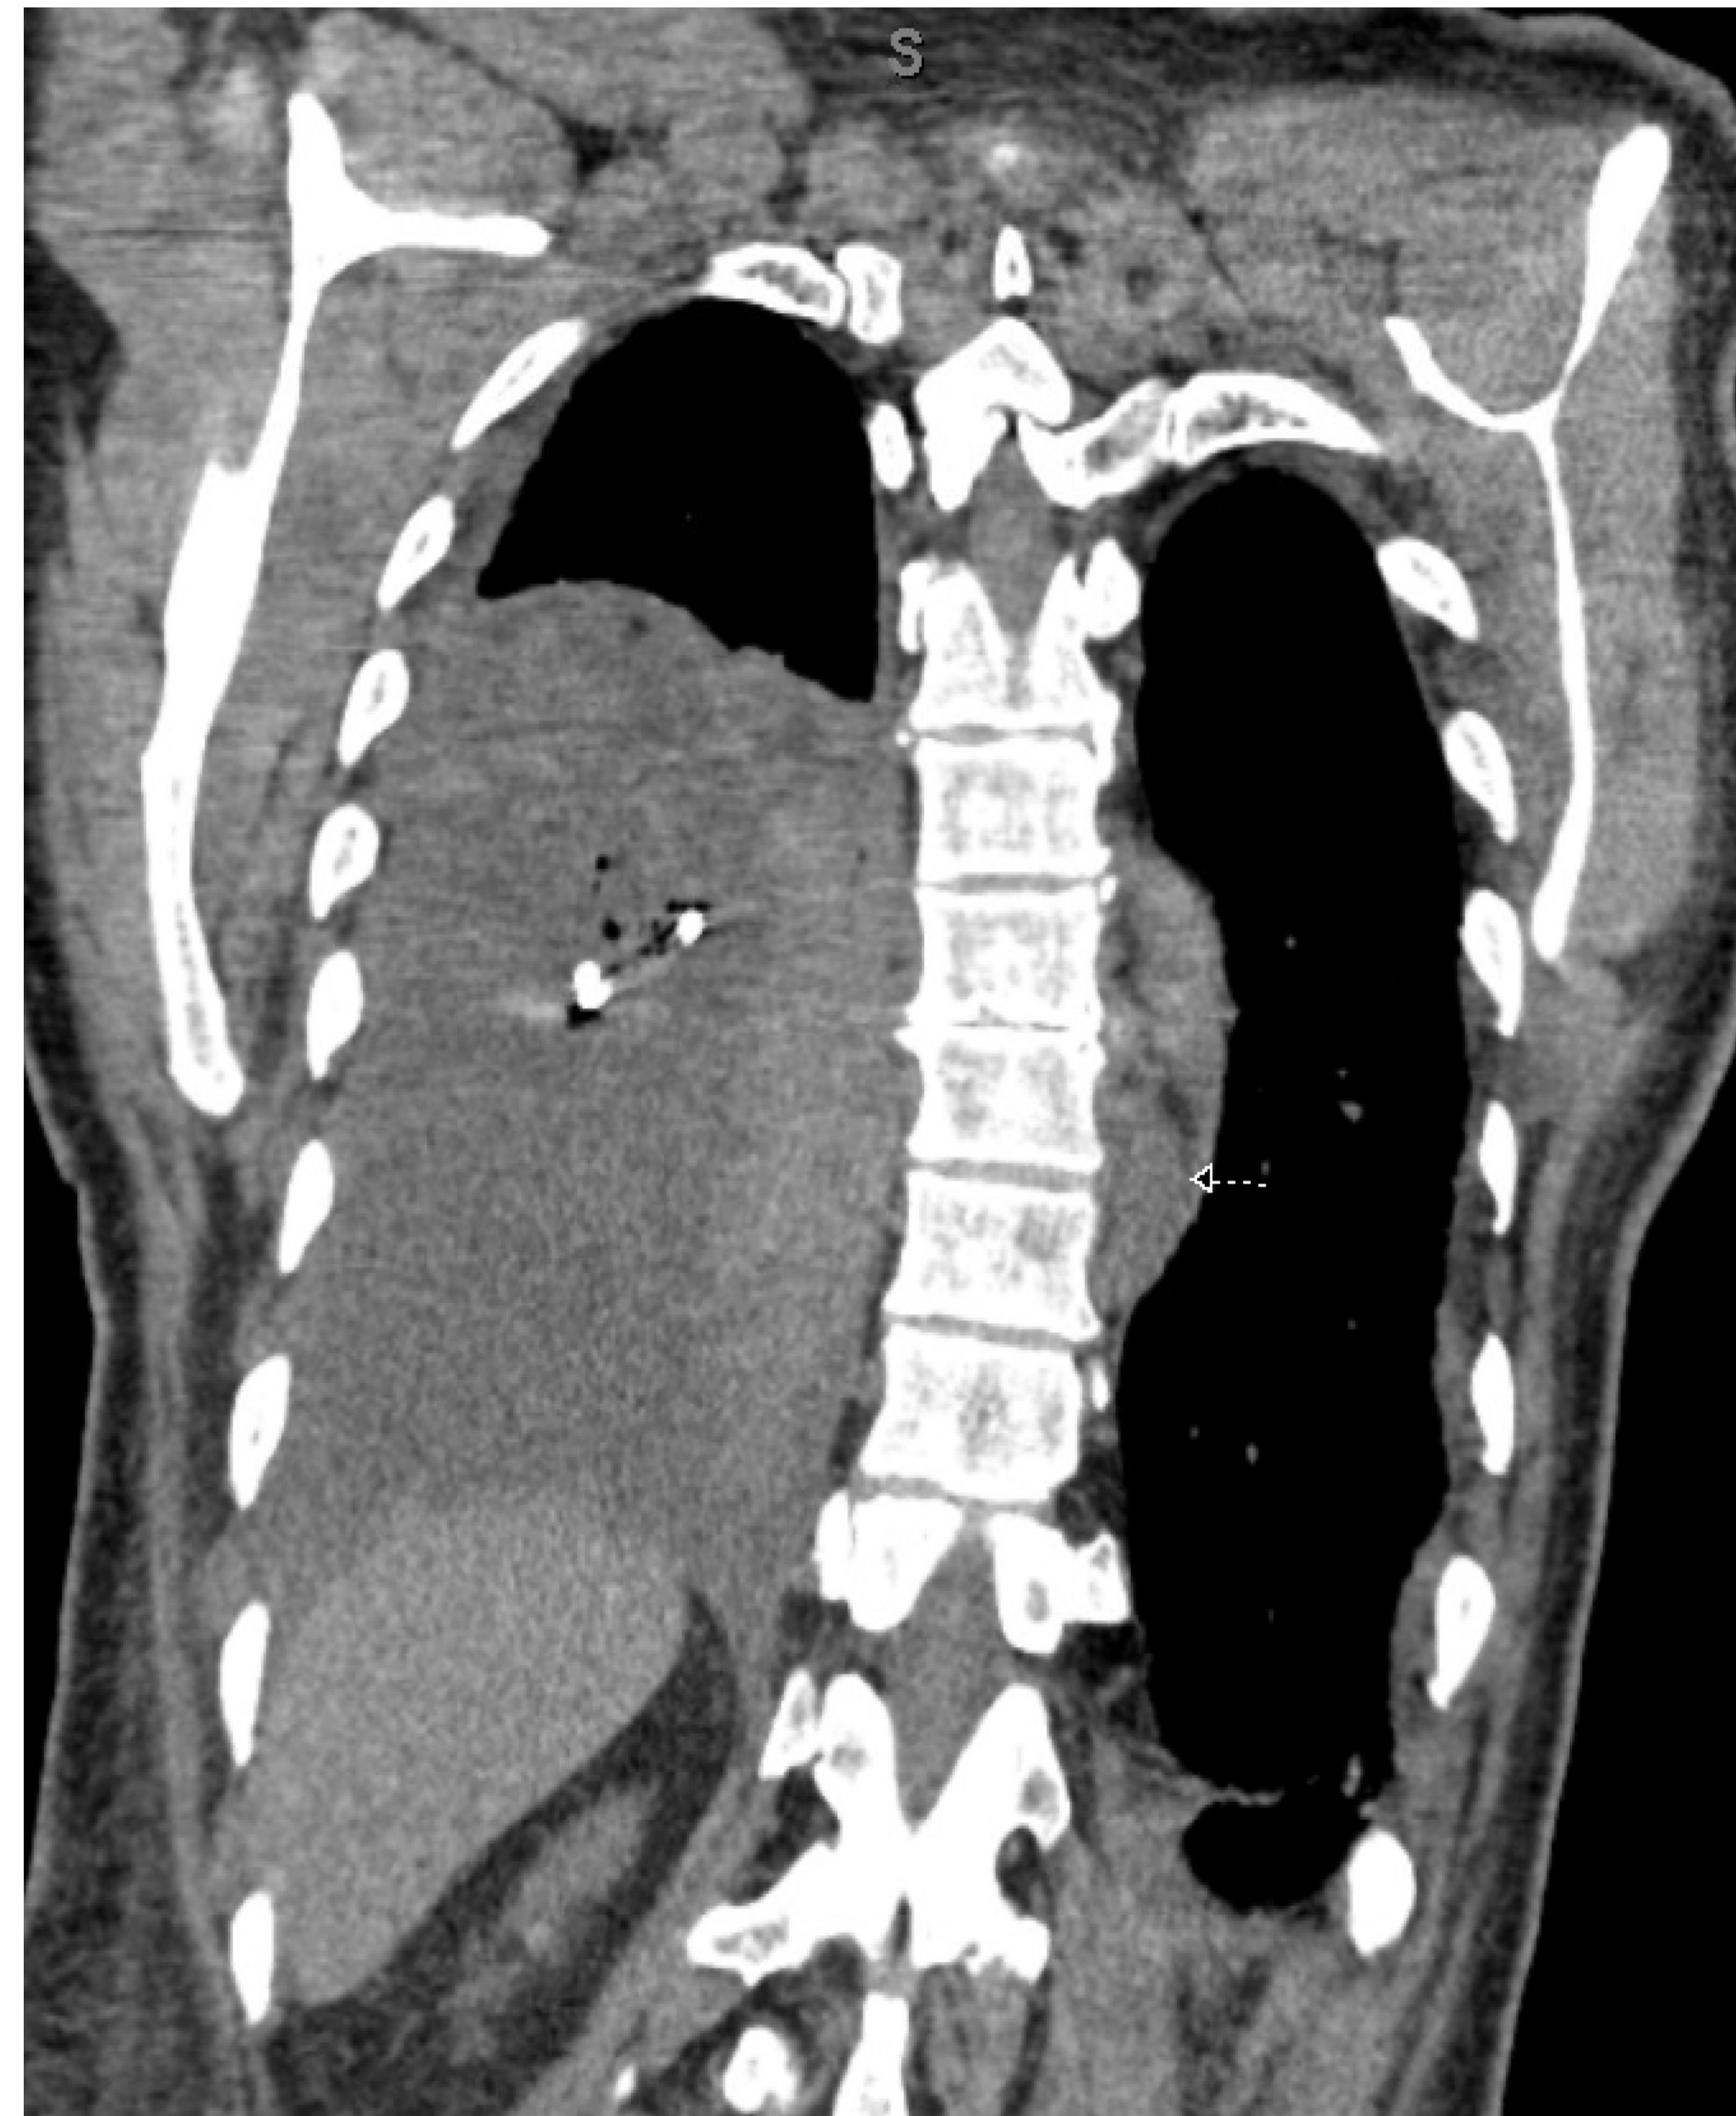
Computed tomography of chest showing endplate erosions and disc space narrowing at thoracic 7 and 8 vertebrae consistent with discitis. An arrow points to the small left paravertebral fluid collection at the same level.
